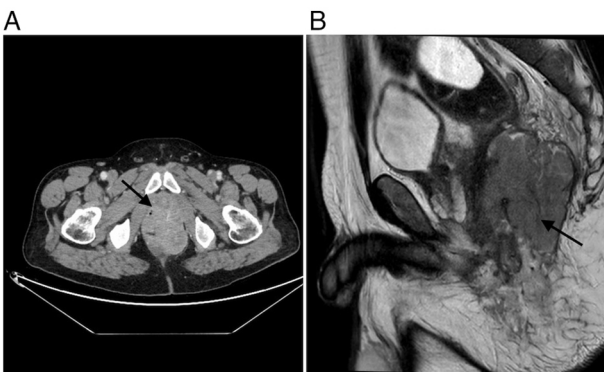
(A) CT scan and (B) MRI findings before radiotherapy treatment (the arrow indicates the tumoral mass).
